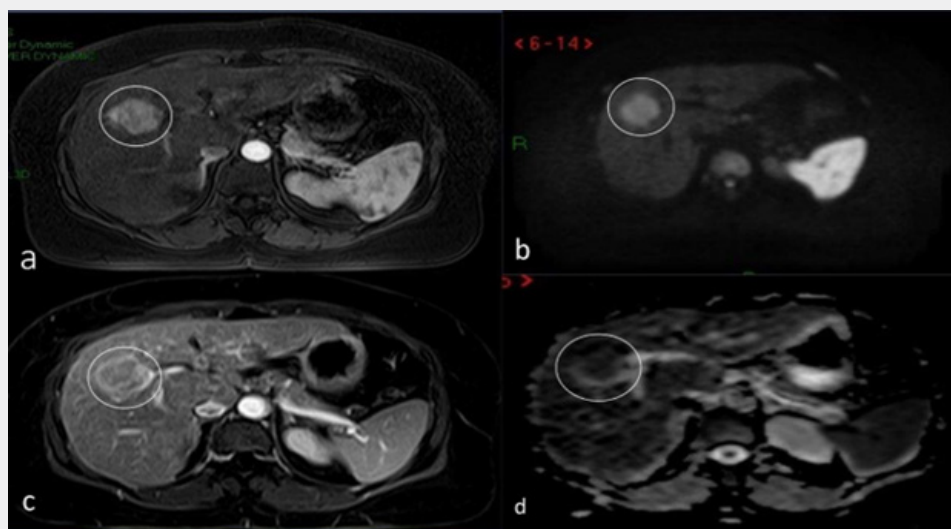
(a) Axial arterial and (c) axial venous phase MRI of liver depicting right lobe lesion showing typical enhancement on arterial phase and washout on venous phase MRI. (b) DWI shows restricted diffusion appearing low on ADC sequence (d) in similar lesion.
